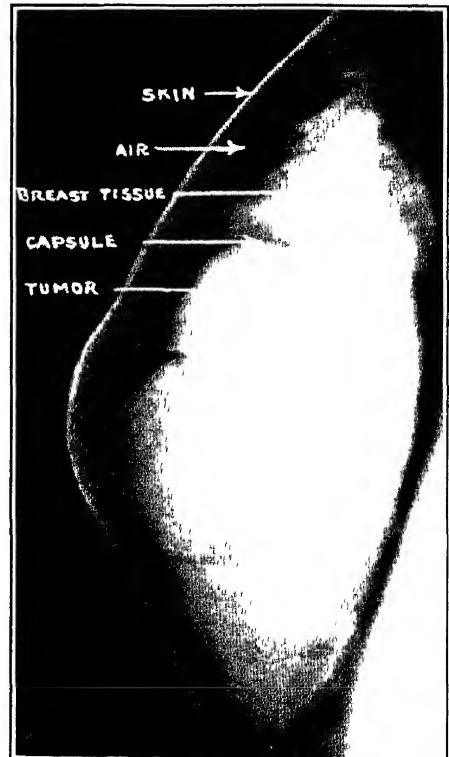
Shows how the air can outline the capsule of a fibroadenoma (Am J Roentgenol., March, 1938)
